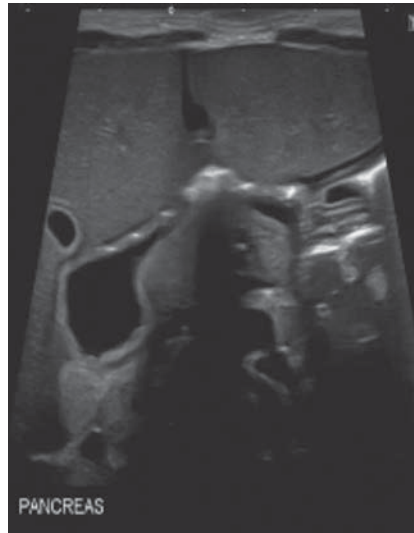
Transverse abdominal ultrasound image shows the remaining small bowel to be completely decompressed, compatible with small-bowel atresia.
